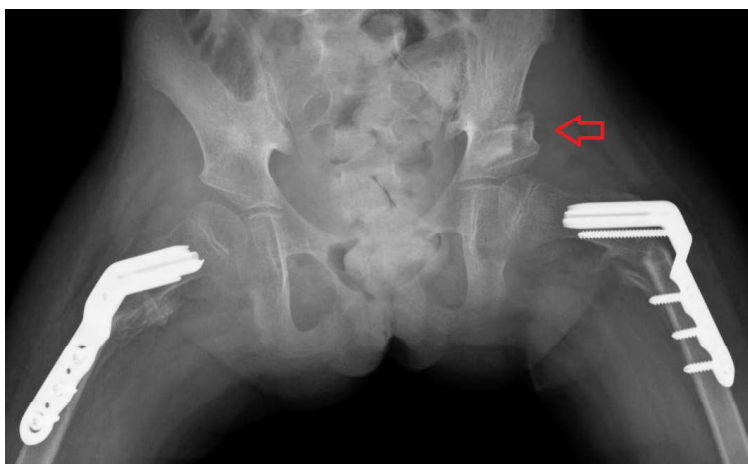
Post-operative anteroposterior radiographic views of the patient shown in Figure 3. The bilateral hip dislocation was relocated with bilateral femoral varus denotational osteotomies of the femurs, as well as a Dega acetabular osteotomy on the left (red arrow).
